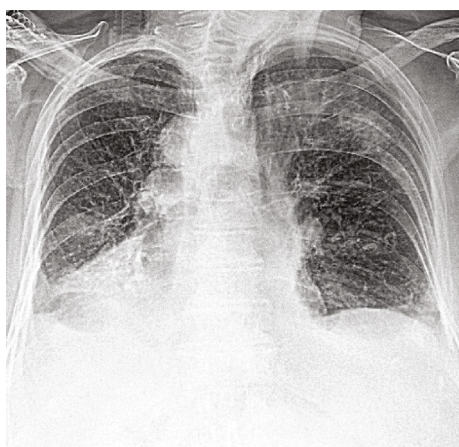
Chest X-ray demonstrating multifocal pneumonia, right-sided aortic arch, cardiac silhouette, and gastric bubble.
